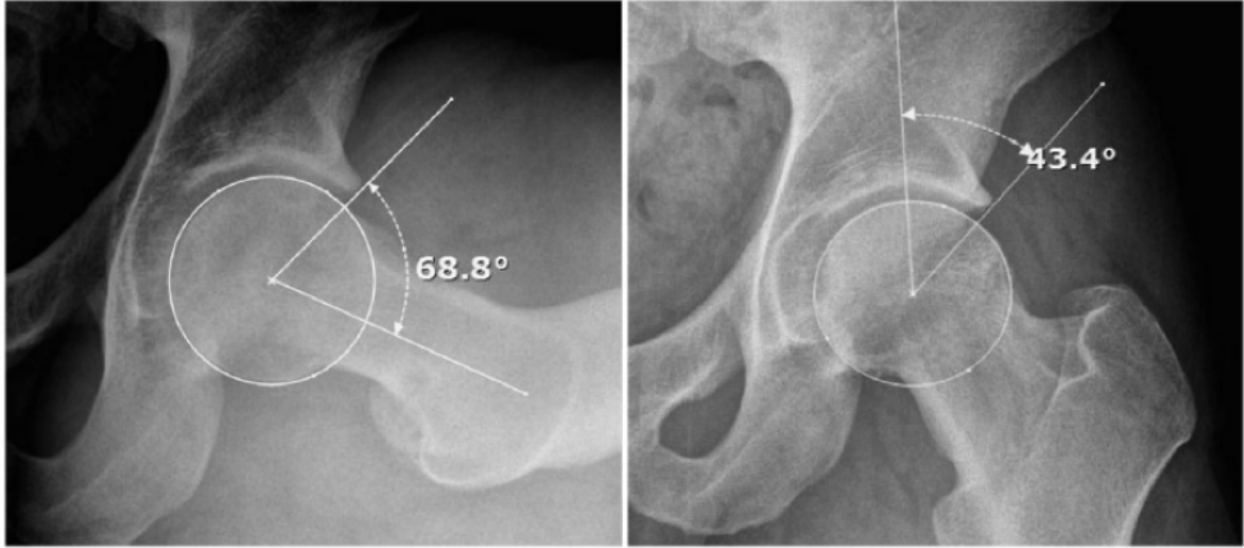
(Left) Radiographic image displaying the circle defining the femoral head, the line connecting the impingement point to the center of this circle and the line along the neck axis all used to calculate the alpha angle. (Right) Radiographic image showing the center-edge angle defined by a vertical line and the lateral most aspect of the acetabulum. Both lines must intersect at the center of the femoral head [28]
